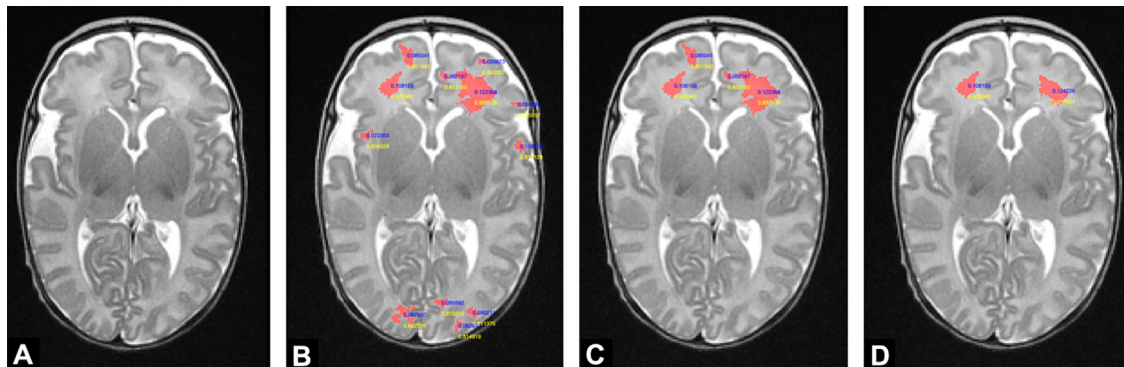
Turbo spin-echo T2-weighted image in the axial plane. DEHSI segmentation was obtained in the same premature male described in Fig. 1, depending on the chosen threshold: 80% in B, 85% in C, and 90% of maximum intensity signal in D.
